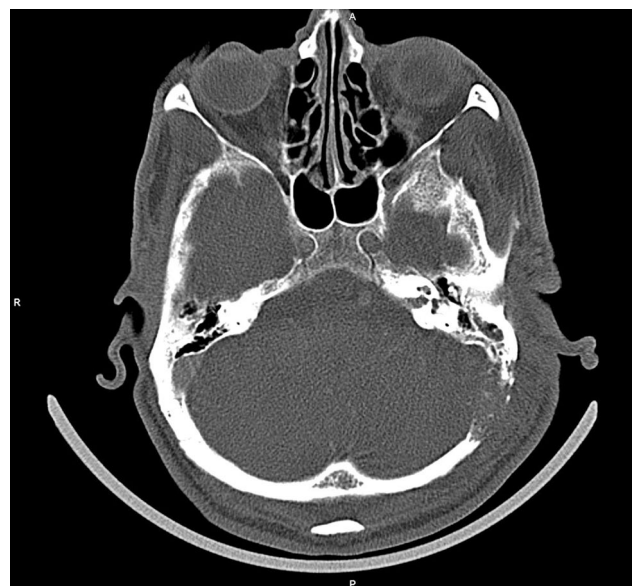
Computed tomography showing the mass that was destructing the mastoid process and occipital bone.
